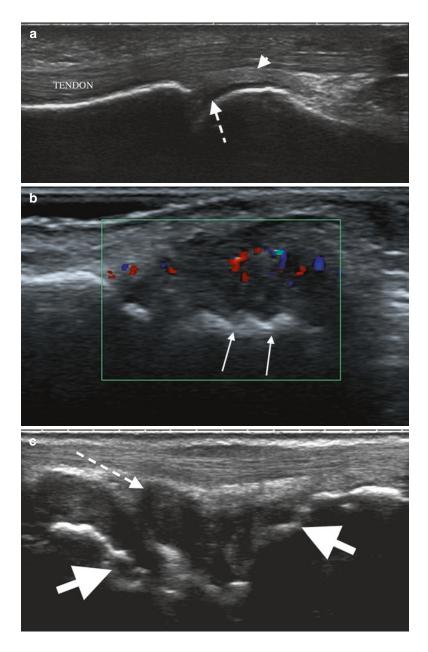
Ultrasound longitudinal images of (a) normal MCPJ that demonstrates overlying flexor tendons, hypoechoic articular cartilage (dashed arrow), and echogenic triangular complex (small arrow). (b) Active synovitis of the MCPJ with early erosions (arrows) that were not visible on x-ray and (c) dorsal wrist with synovitis (dashed arrow) and multiple erosions of the carpal bones (arrows)
